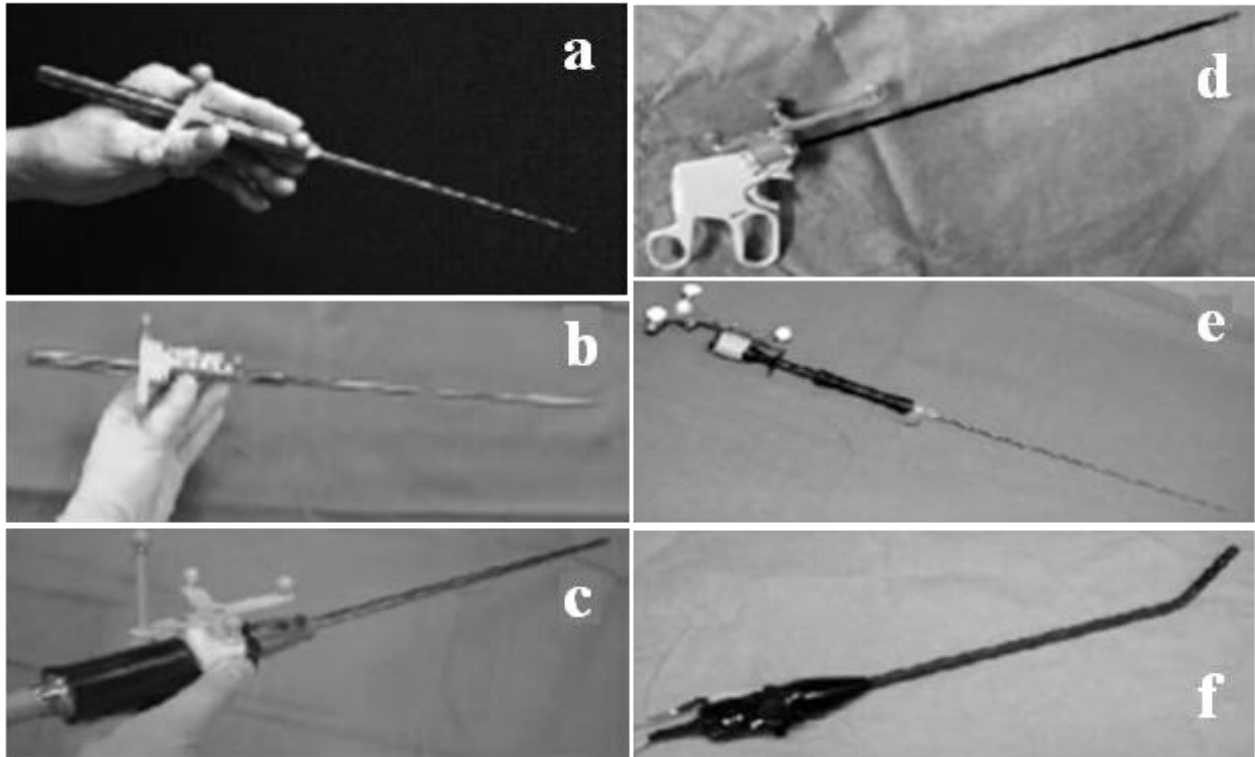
The prototype surgical navigation system, proposed by Lango et al.; various surgical tools that could be tracked by the proposed system: (a) a preoperative planning pointer that could be used for patient registration, (b) a dedicated intraoperative laparoscopic pointer, (c) a video laparoscope, (d) a grasper for navigation during resection, (e) a radio frequency ablation probe, (f) a flexible ultrasound probe with electromagnetic tracking sensors on the tip [49]. Used with permission.
